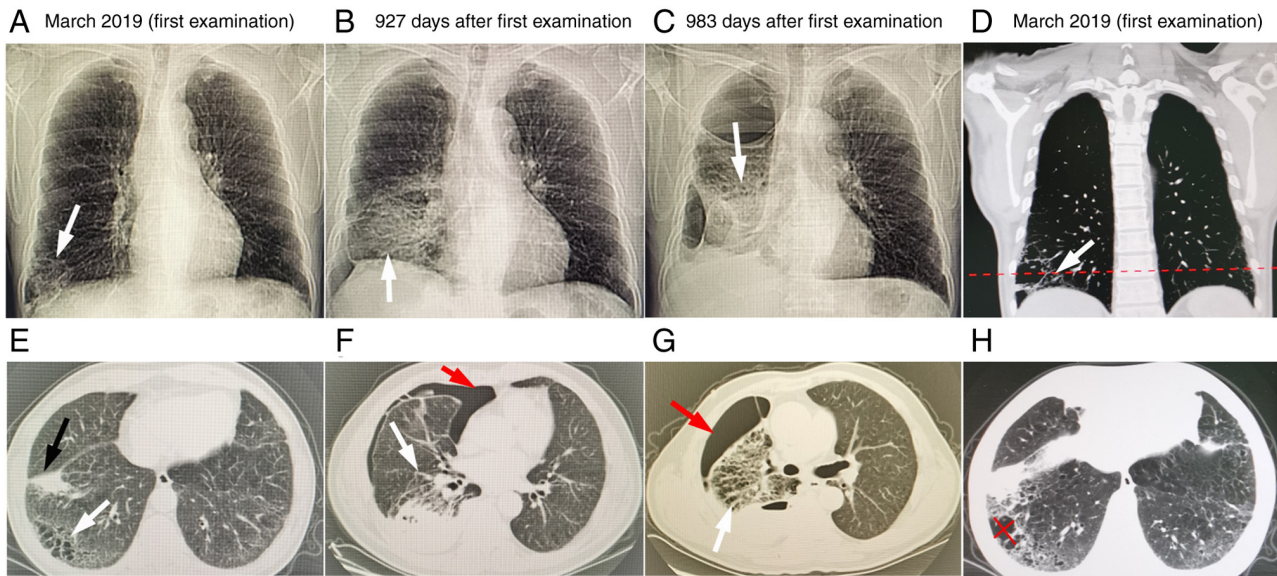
Chest HRCT (localization phase) of pulmonary cystic lesions (white arrow) in (A) March 2019, (B) October 2021 and (C) December 2021. (D) HRCT (coronal reconstruction) showing tumor angiogenesis (white arrow). (E) HRCT (transverse section) showing right lung mass lesion (black arrow) and cystic lesion (white arrow) in March 2019. HRCT (transverse section) showing cystic lesion (white arrow) and right pneumothorax (red arrow) in (F) October 2021 and (G) December 2021. (H) HRCT (transverse section) showing tumor angiogenesis, with a measured length of 40.1 mm and width of 24.9 mm (dimensions of the tumor as indicated by the red lines). HRCT, high-resolution computed tomography.
